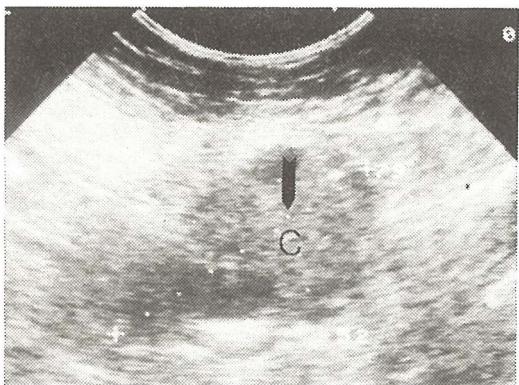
Sonographic scan of a relapse of sigmoid cancer (C)
